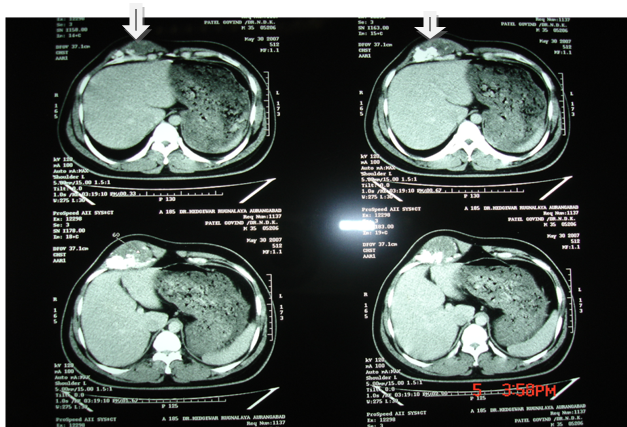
CT scan showing tumor
